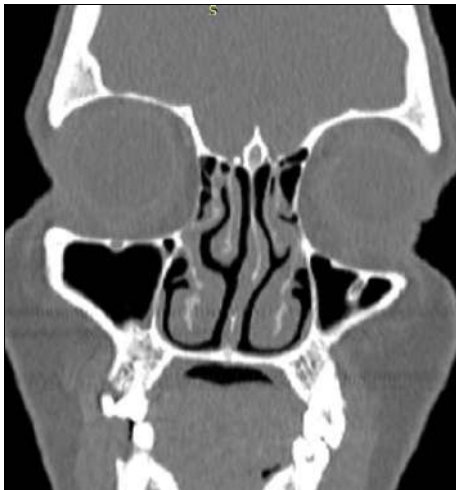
Coronal CT section showing deviated nasal septum towards left side
